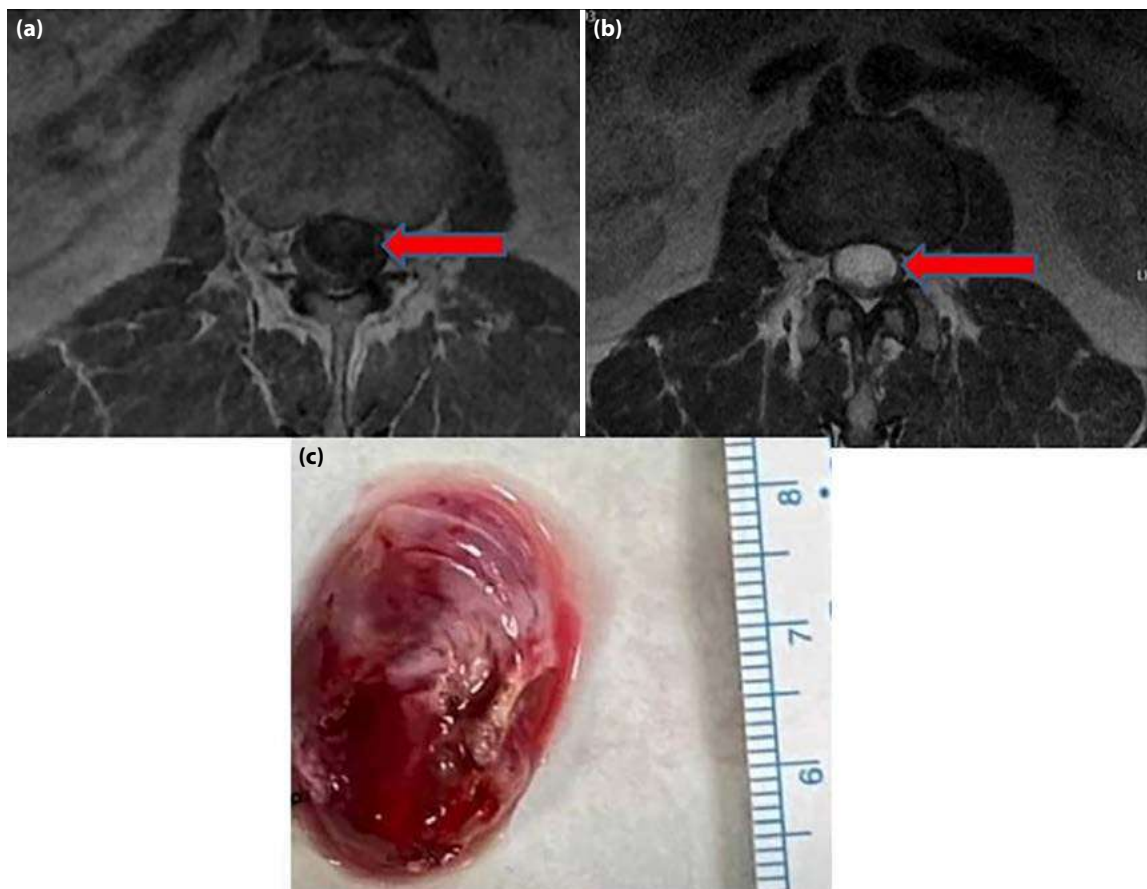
T1 (a), T2 (b) magnetic resonance images on the axial plane, and macroscopic appearance of the lesion (c).
